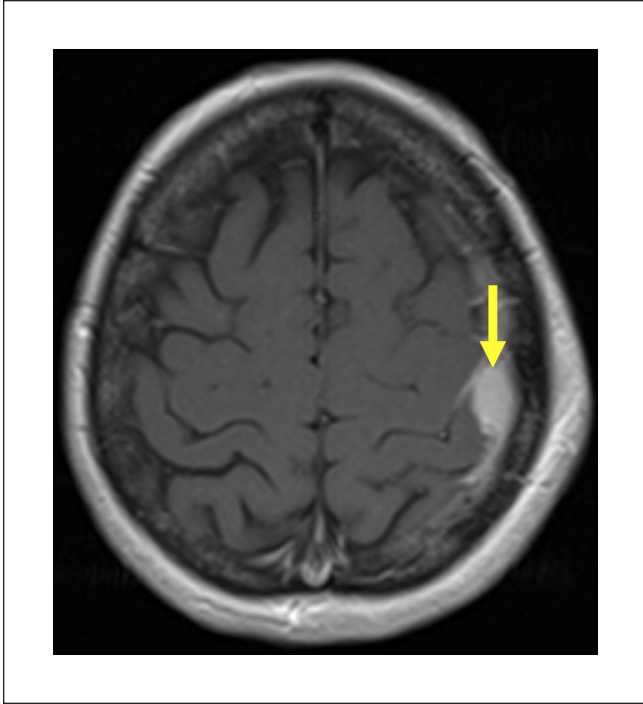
Coronal (left) and axial (right) magnetic resonance images demonstrating a $2.3 \times 1.0 \times 2.7$ cm dural-based mass (yellow arrows) in the left frontoparietal region with associated thickening and enhancement of the adjacent dura. There is an extracranial component to the mass in the adjacent soft tissues without visible abnormalities of the bone. In addition, there are linear extension into the gyri of the adjacent brain parenchyma with an associated focal area of subcortical edema in the lateral aspect of the postcentral gyrus.
